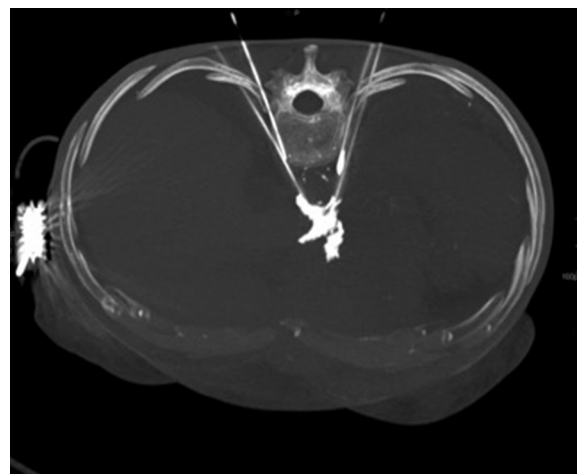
A computed tomography volume maximum intensity projection in a patient undergoing combined celiac and splanchnic neurolysis from a posterior approach demonstrating needle positions and contrast spread
